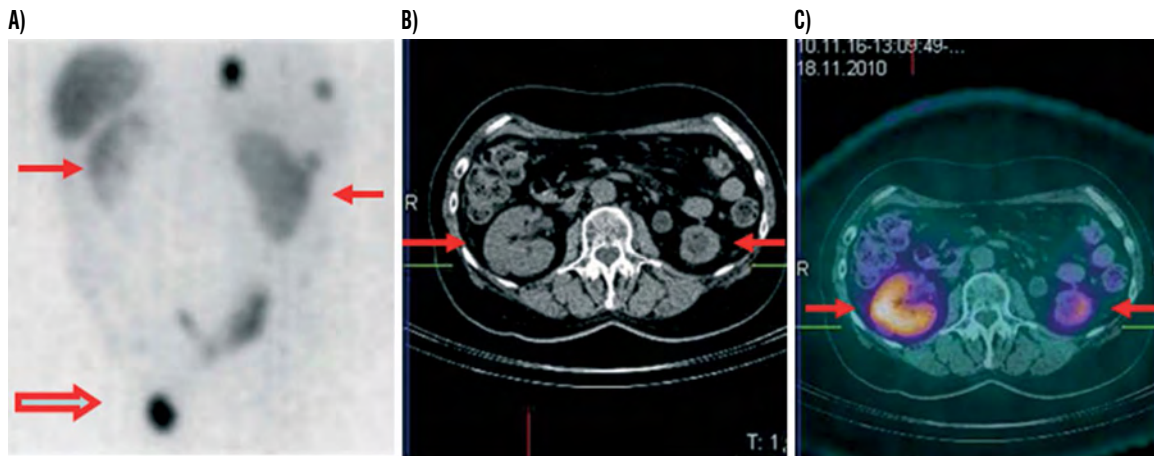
177-Lu octreotide for radionuclide therapy (PRRT) of inoperable NETs. (A) MIP: kidneys – arrows, tumour- open arrow, (B) CT and (C) fused SPECT/CT images of kidneys (arrows) needed for dosimetry calculations. Kidneys are critical organ for therapy with radiolabelled octreotide.
